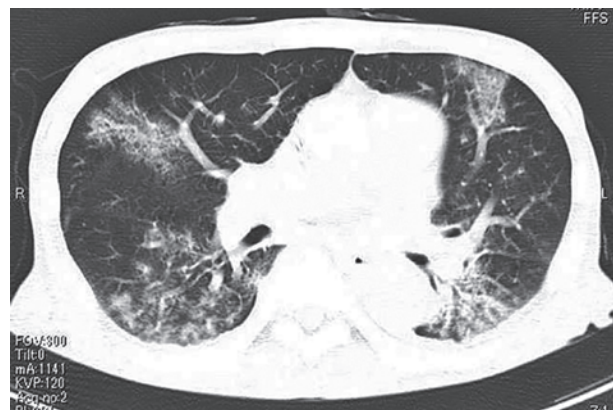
Chest CT 7 days after respiratory syncytial virus diagnosis (Case 3)
